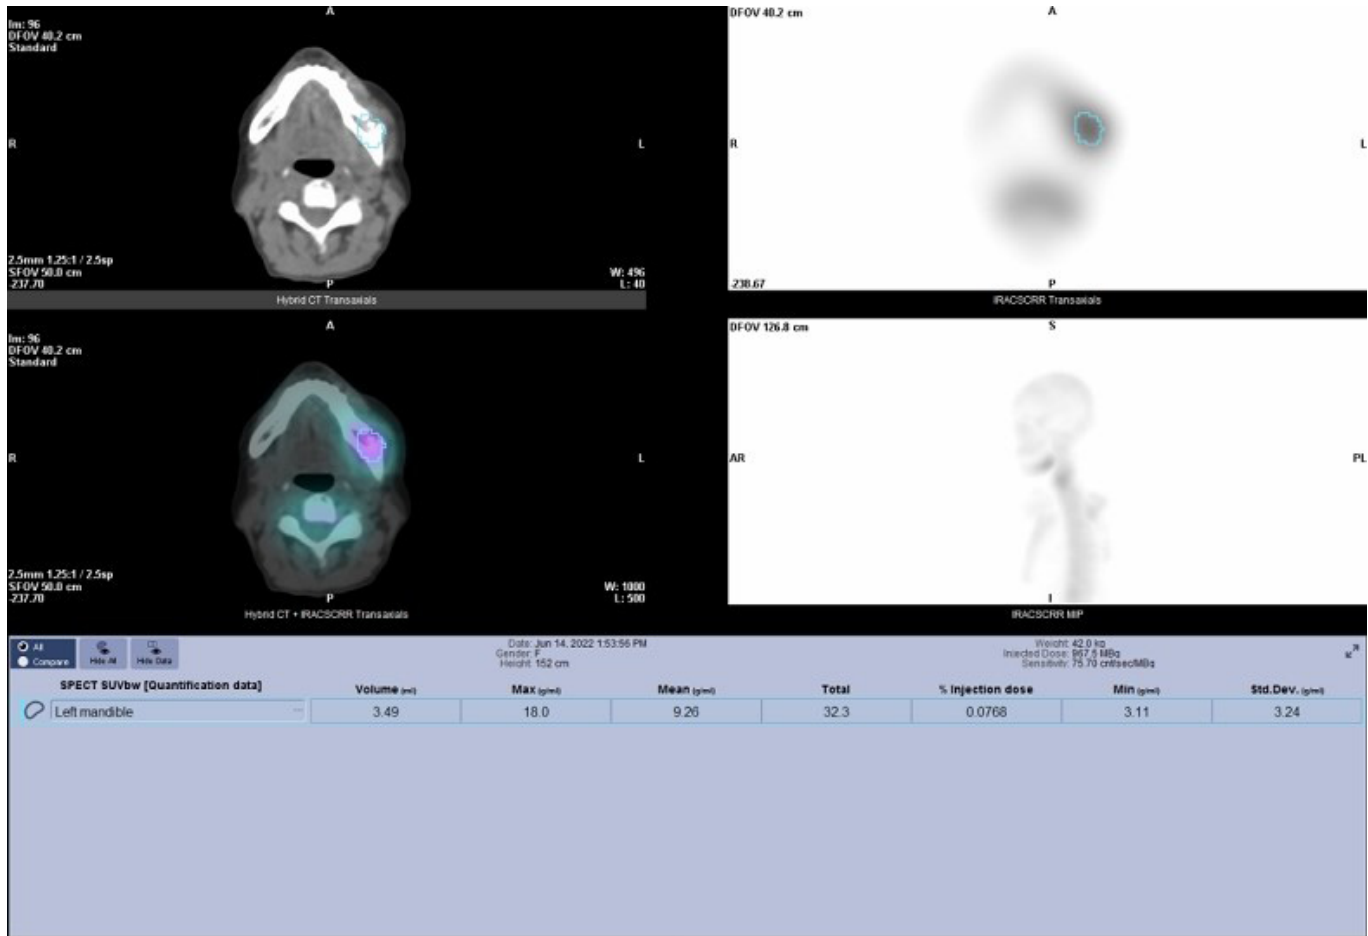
Medication-related osteonecrosis of the jaw of the left side of the mandible in a 61-year-old female. ^{99m}Tc-hydroxymethylene diphosphonate accumulation was shown in the left mandible. The volume of interest (sky blue) was set on lesion. Maximum SUV and mean SUV were 18.0 and 9.26, respectively.
